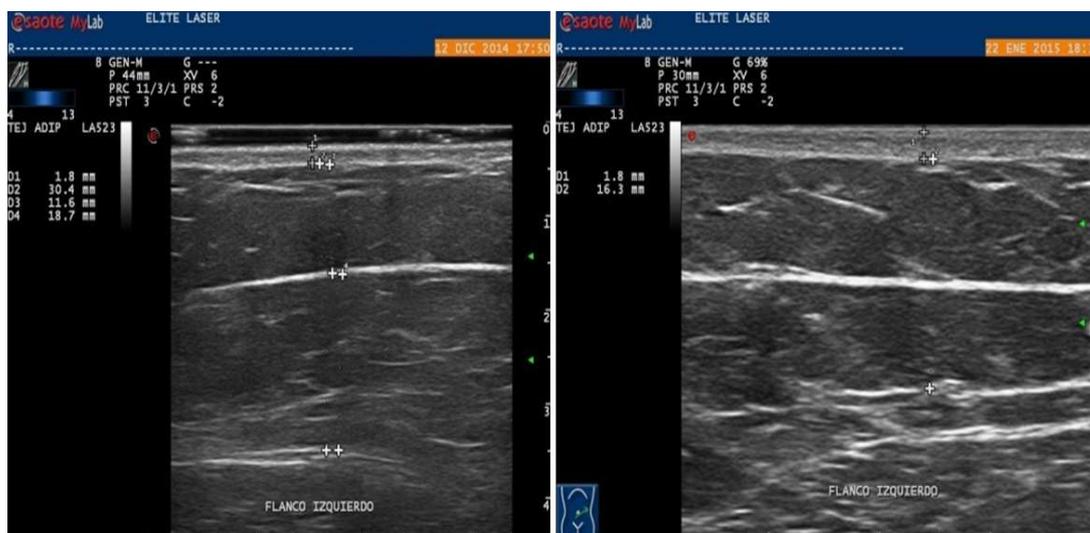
Mode B ultrasound. Left flank treated with Aqualyx®. 30.4 mm SPA before treatment (left) and 16.3 mm SPA one month after treatment (right).
